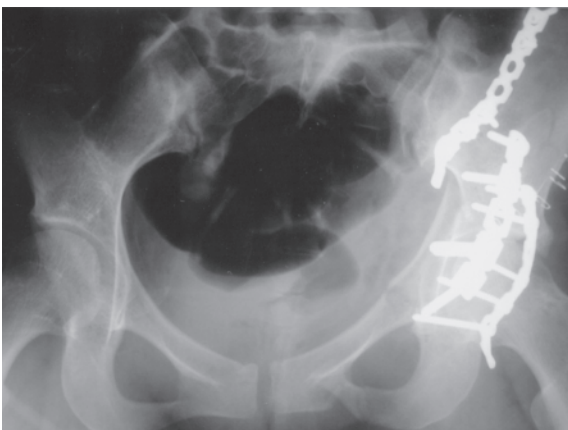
Post-operative AP radiograph shows a residual 2 mm displacement.
